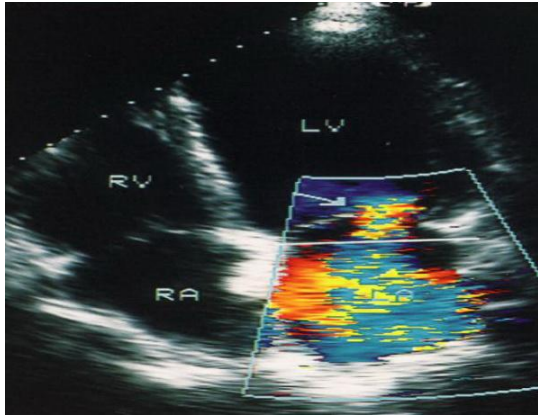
Shows color Doppler examination showing MR
